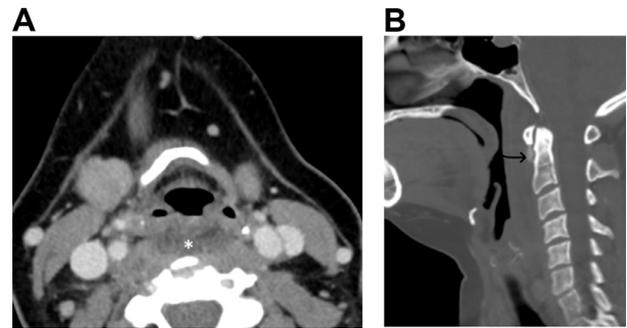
Acute calcific tendonitis of the longus colli. Thirty-seven-year-old female presenting with neck pain. Axial contrast enhanced CT neck (A) reveals retropharyngeal fluid and prevertebral soft tissue edema (*), the fluid in retropharyngeal space does not cause anterior convexity hence is unlikely to be an abscess. Sagittal bone window reconstruction (B) revealing amorphous calcification of the longus colli muscle (arrow) at C1-C2 level.
